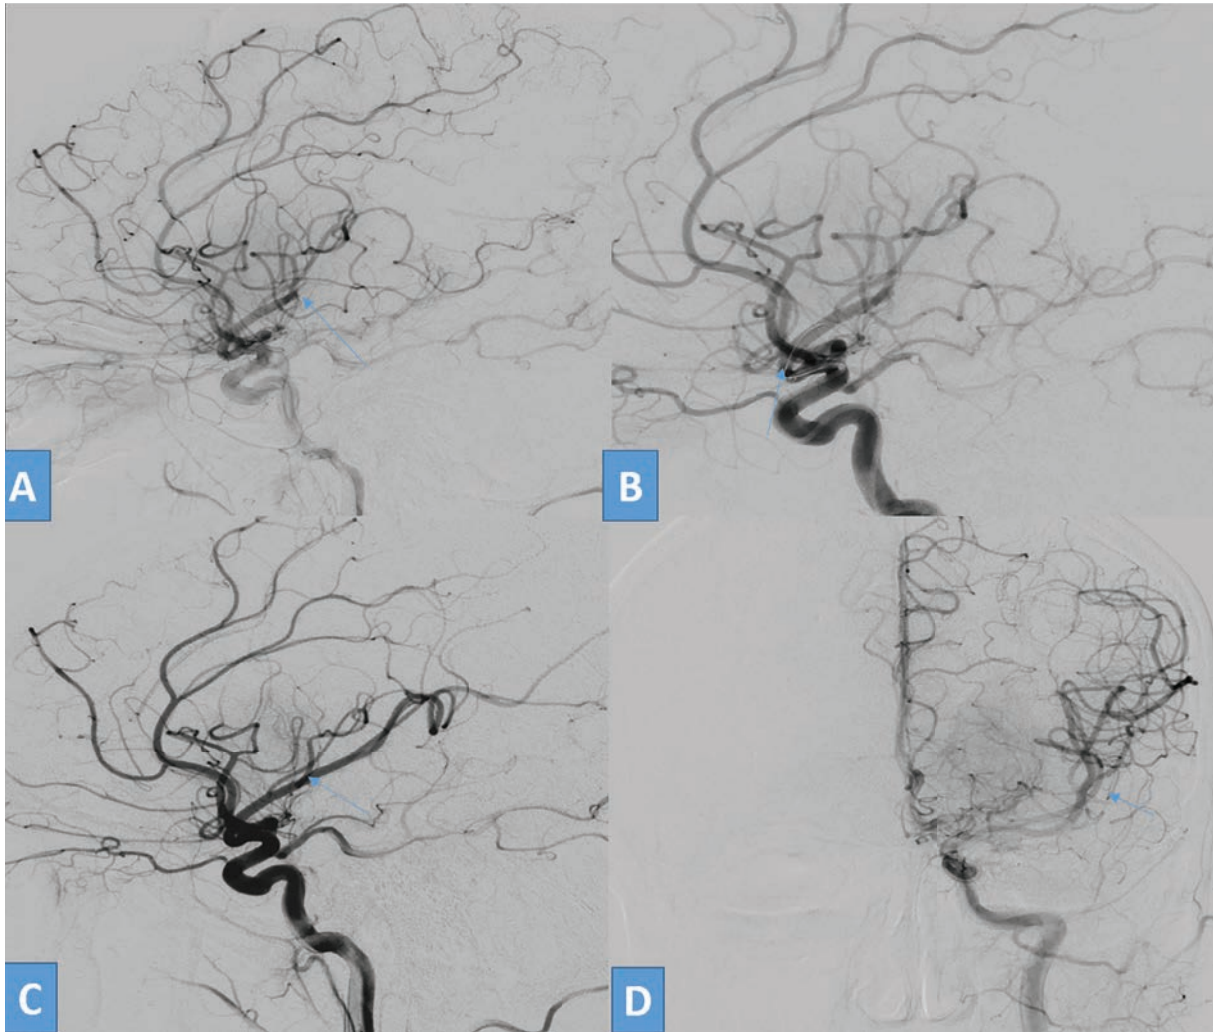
A 48-year-old patient with a history of mitral valve replacement, presented with acute ischemic stroke for 3 hours. She was E4V5M6 with NIHSS 10 with aphasia. NCCT ASPECTS was 9 with good collaterals. Mechanical thrombectomy was done under local anaesthesia. (A) Left ICA DSA lateral view shows cut off (arrow) in the distal segment of M2 MCA inferior division. (B) Microwire and aspiration catheter (3 Max penumbra) assembly. (C) After a single aspiration ADAPT, the check run shows a complete opening of the inferior division (arrow). (D) AP view of left ICA angiogram shows recanalisation of the inferior division of M2 MCA with slow distal flow. (Modified TIC1 2b recanalisation.)
